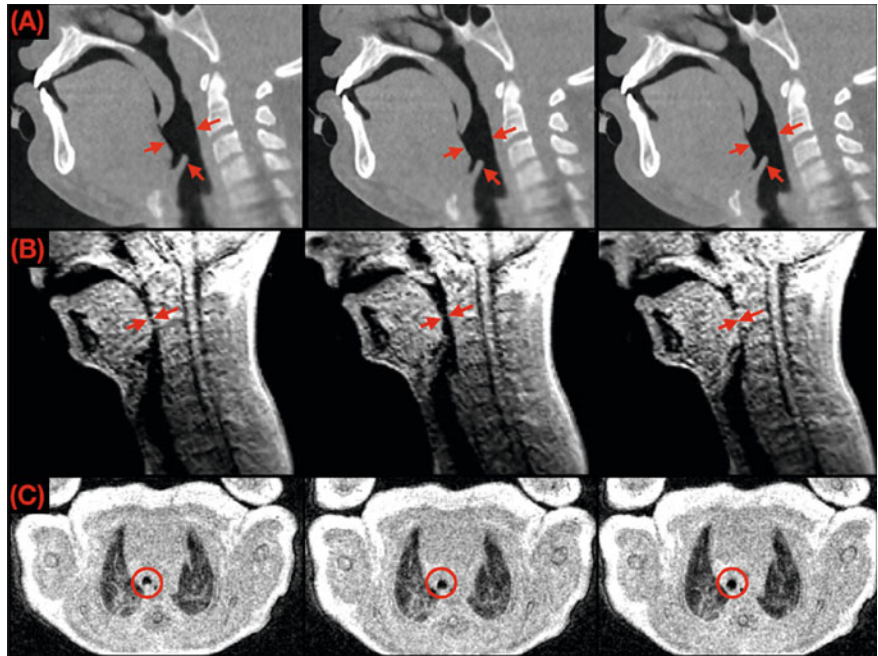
a A sagittal slice through the upper airway of an 18-year-old patient with OSA taken from a 4D dynamic CT image. The slice is shown at three instants through a breath. There is a subtle change in caliber of the retroglottal airway and the epiglottis moves anteriorly (red arrows). b A sagittal slice through the upper airway of an 11-year-old patient with OSA at three instants taken from real-time cine MRI. The retroglottal airway caliber starts narrow (left image, red arrows), widens (central image), and then collapses completely (right image). c An axial slice showing the intrathoracic trachea in a neonatal patient with tracheomalacia at three instants. In the first image (left), the rear wall of the trachea has collapsed inwards creating a “D” shaped lumen (red circle). In the central image, the rear wall has started to move posteriorly, and it keeps moving until the trachea is almost circular (right image)
